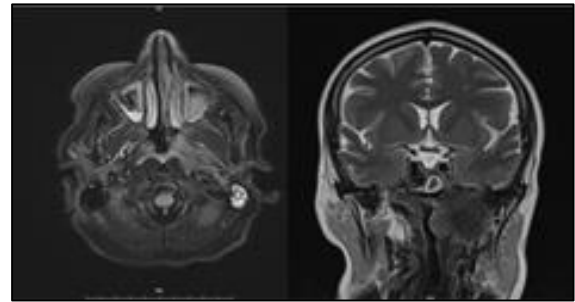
The axial and coronal T2-weighted MRI of the patient.
